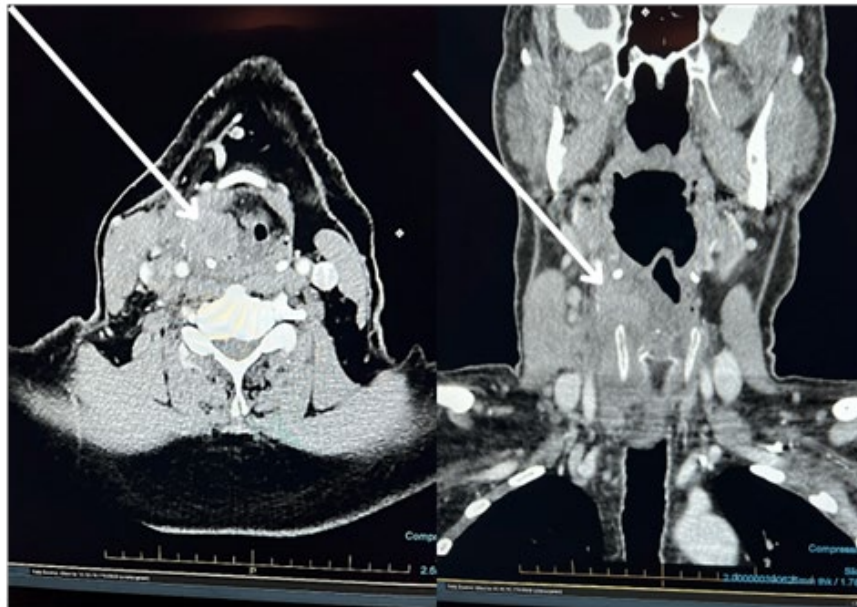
Axial and Coronal Imaging of neck mass by computed tomography
